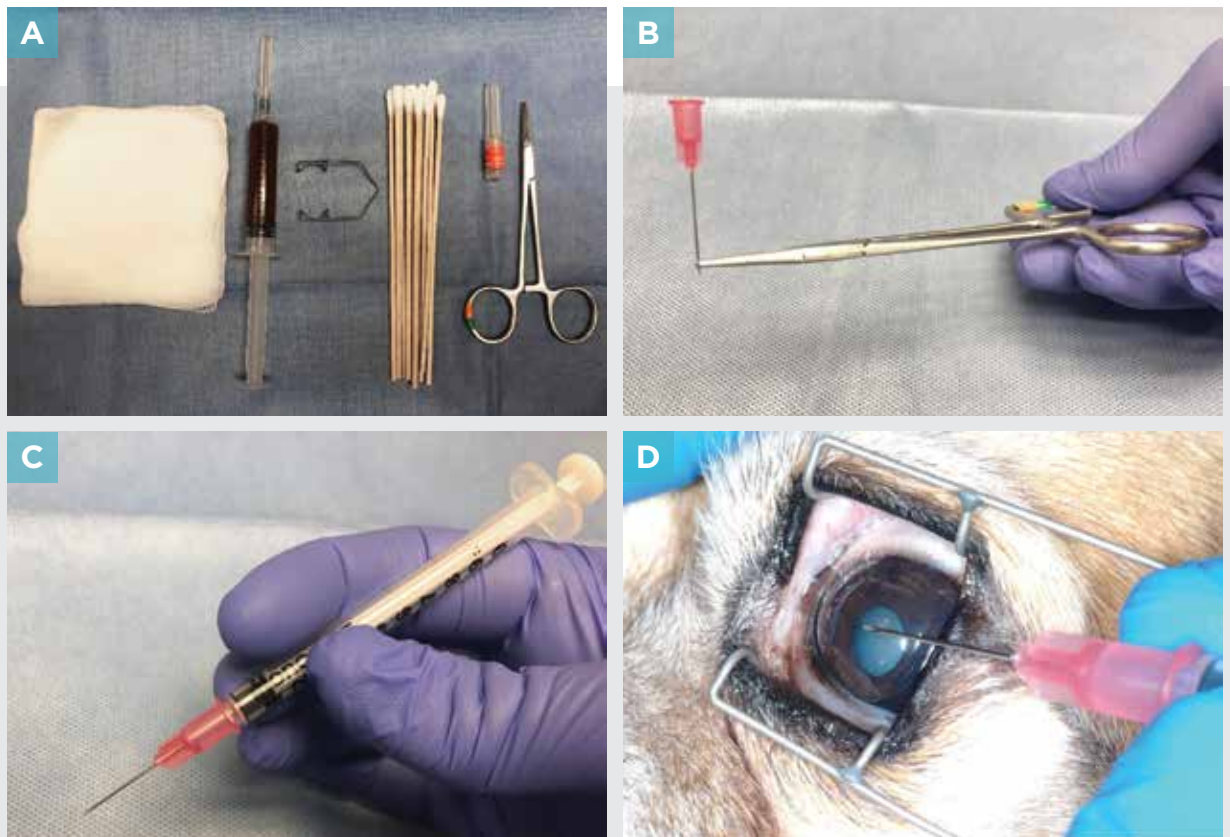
Grid keratotomy. (A) An example of the tools needed for a grid keratotomy from left to right: 4×4 gauze, dilute betadine solution, sterile eyelid speculum, sterile cotton-tipped applicators (CTAs), 25-gauge needle, and a sterile hemostat. (B) If using a standard 25-gauge needle for a grid keratotomy, it can be grasped near the tip by the sterile hemostat with approximately 1 mm of the needle exposed. (C) Alternatively, a sterile syringe attached to a 25-gauge needle can be used to perform a keratotomy. Some individuals may find this simpler or more comfortable; it's a personal preference. (D) Preparing to start a grid keratotomy on a patient. An eyelid speculum may be used to keep the lids open, and/or a sterile CTA can be used to keep the third eyelid out of the way, as seen in FIGURE 2. Note the acute (almost parallel) angle of the needle in relation to the surface of the eye. The needle should never be perpendicular to the eye's surface. Note: This photo is staged as an example and this cornea is normal.
